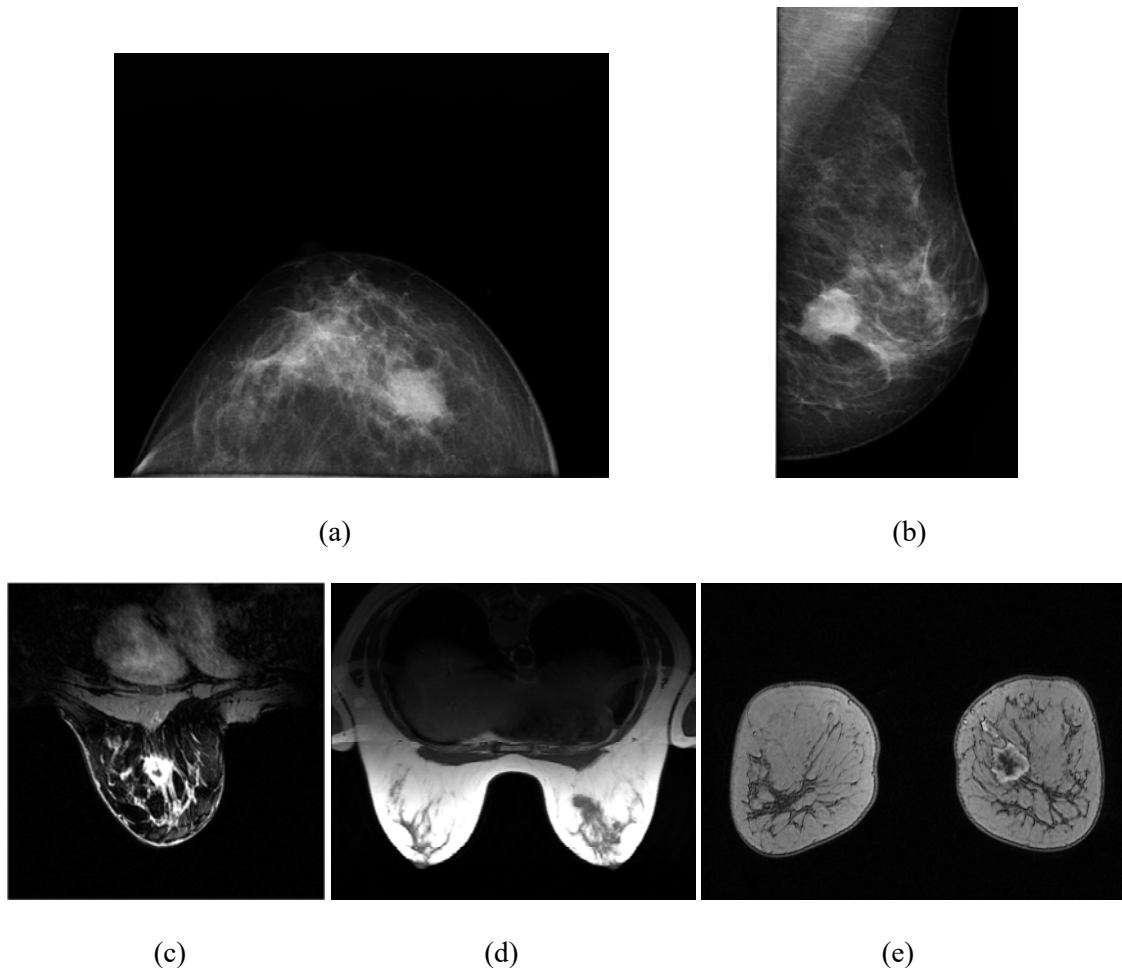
Clinical images from the patient's left breast showing the presence of a tumor. Mammograms taken in two compression directions: (a) CC and (b) MLO. MR images in anatomical planes: (c) sagittal, (d) axial and (e) coronal.
